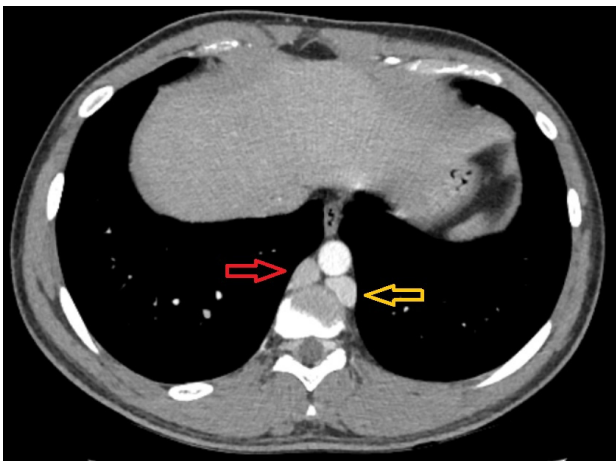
Axial view of contrast enhanced CT scan of IVCA showing dilated right azygos vein (red arrow) and dilated left hemiazygos vein (yellow arrow)
